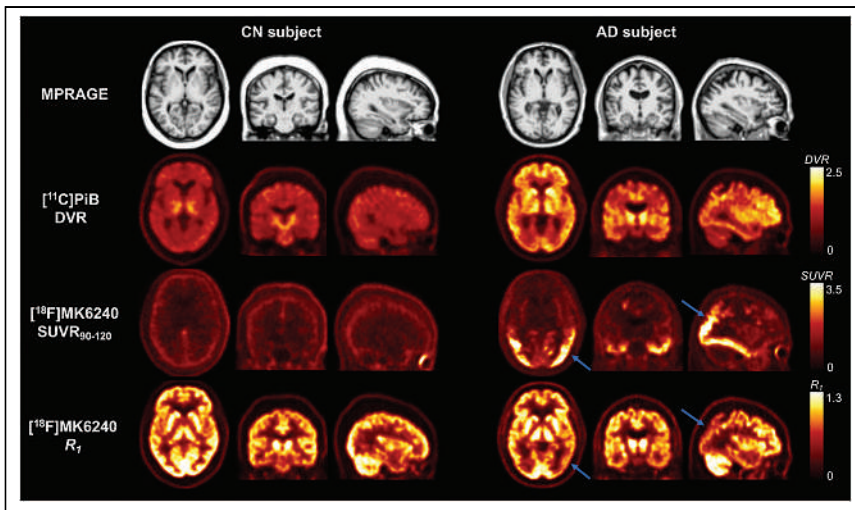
Parametric maps and corresponding MR structural images in CN subject and AD subject. First row shows magnetization-prepared rapid gradient echo as anatomic reference. Second row shows parametric $[^{11}\text{C}]\text{PiB}$ DVR images as measure of amyloid burden. Third row shows late $[^{18}\text{F}]\text{MK6240}$ SUV ratio for images from 90 to 120 min as measure of tau load. Fourth row shows parametric images of R_1 computed from $[^{18}\text{F}]\text{MK6240}$ dynamic data. Arrows indicate areas of reduced cerebral perfusion and corresponding to high tau load. MPRAGE = magnetization-prepared rapid gradient echo; DVR = distribution volume ratio; SUVR = SUV ratio; SUVR_{90-120} = SUV ratio for images from 90 to 120 min.
